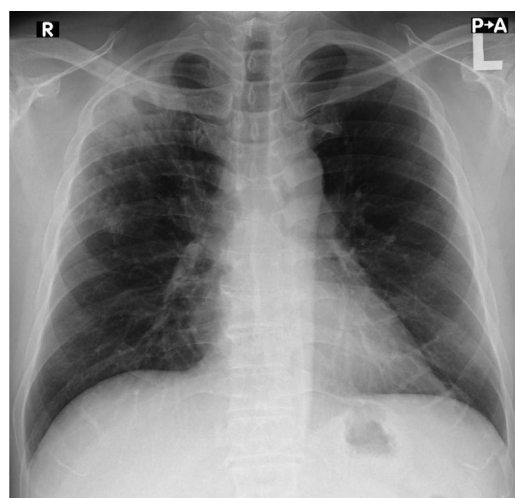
Patient's chest radiograph. Cavitated consolidation indicating lung abscess was seen in the upper right lung field
